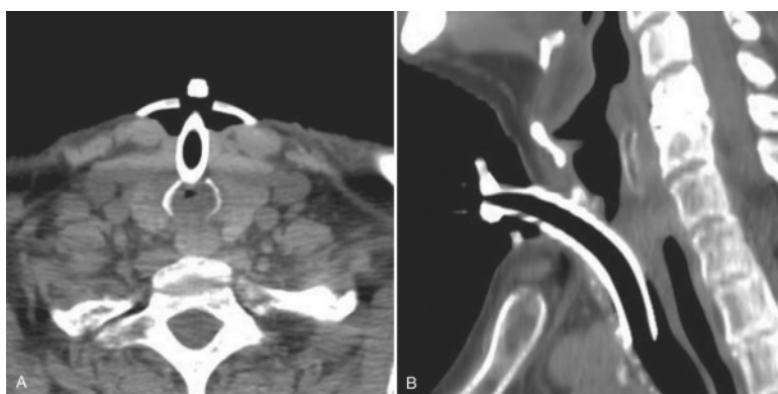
Axial (A) and sagittal (B) computed tomography scans (soft tissue algorithm) in a patient with laryngotracheal stenosis. The tracheotomy is entering the airway just distal to the stenotic segment.
